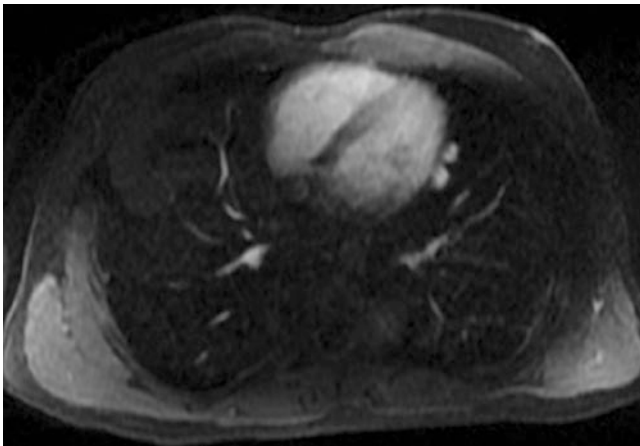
MRI of the chest in a patient with metastatic Ewing's sarcoma. This post-contrast-enhanced fat-suppressed image demonstrates two pulmonary nodules in the lingula, adjacent to the pericardium
